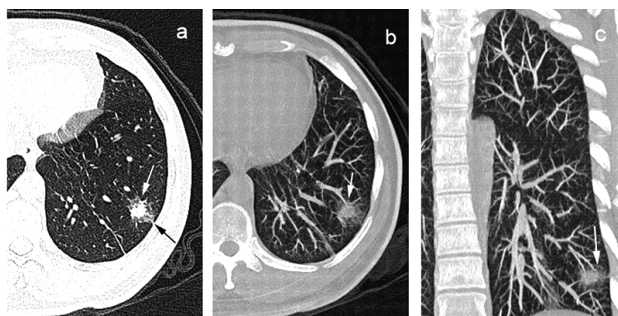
CT characteristics of a 46-year-old female patient. MIA of the left lower lobe of the lung. (a) CT plain scan showed mixed ground-glass density, dominated by solid density. The size of the lesion was about 25.9 × 20.9 mm. The margin was irregular and the lobulation sign (white arrow) and adjacent pleural traction (black arrow) could be observed. (b) The tumor vascular sign after MIP recombination. (c) The coronal position of the MIP recombination showed that blood vessels entered the lesion. MIA, minimally invasive adenocarcinoma; MIP, maximum intensity projection.
